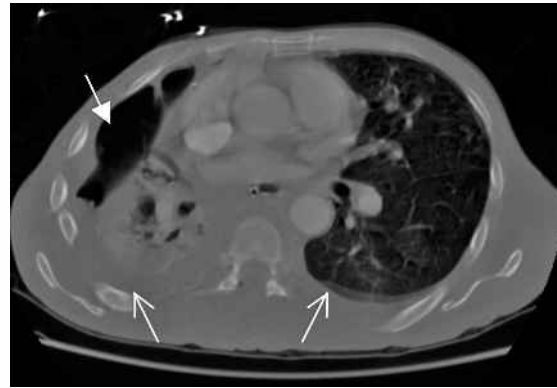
CT image of the thorax shows a right pneumothorax (bold arrow) with collapse of the underlying right lung and bilateral effusions (arrows).
